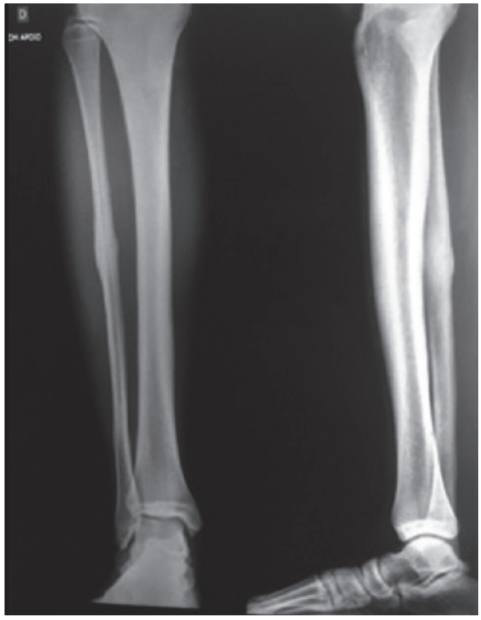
Radiograph with healing of the fibula bone.
